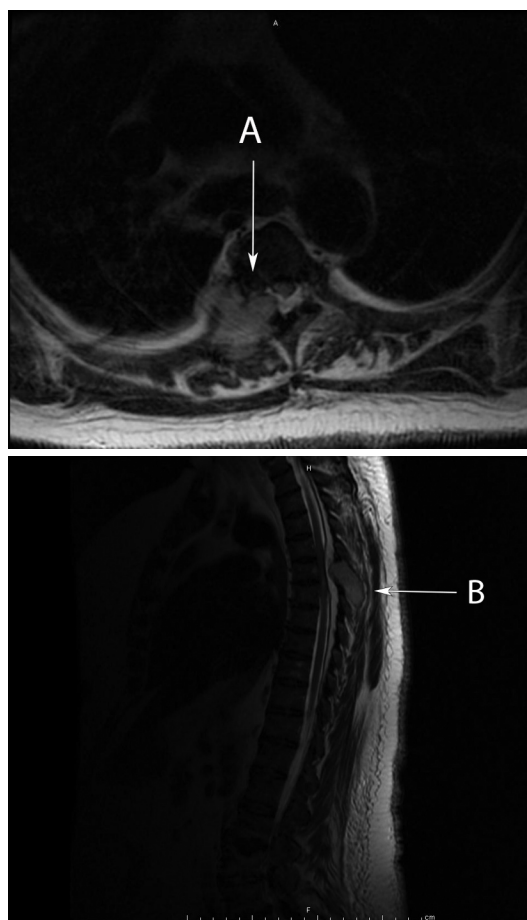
T2-weighted MRI demonstrates the T5 vertebral metastasis with destruction of the body and posterior elements and spinal cord impingement (A, B).
